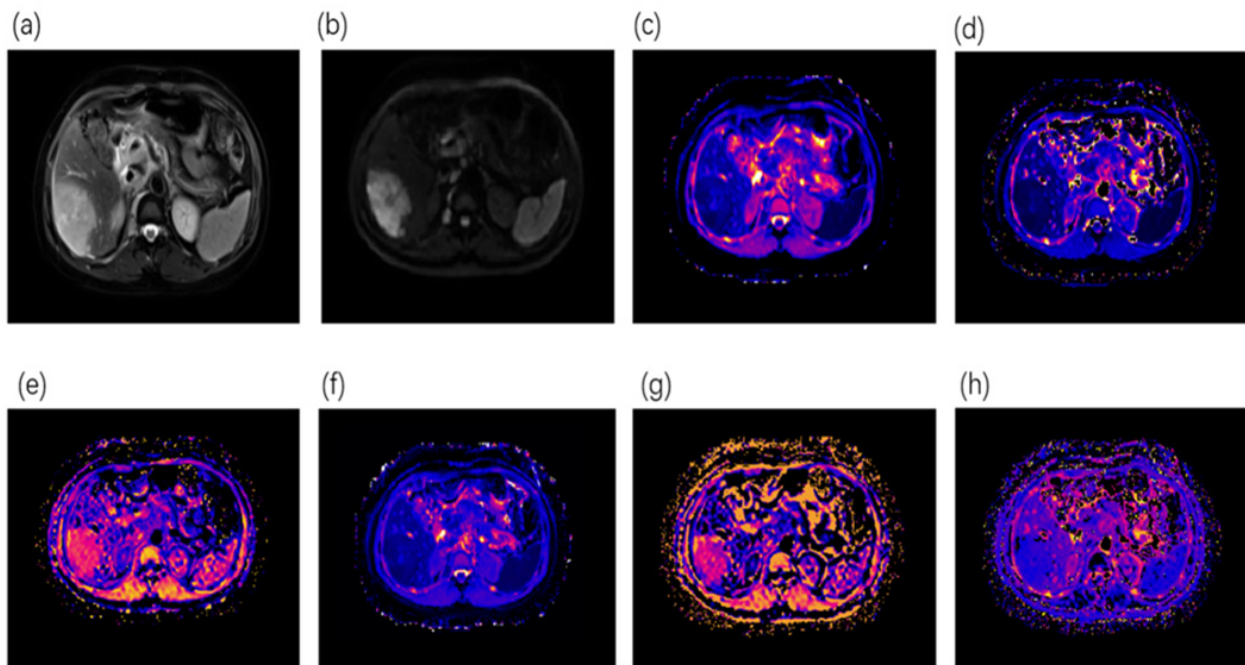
MRI images of a patient with pathologically confirmed intrahepatic cholangiocarcinoma.
